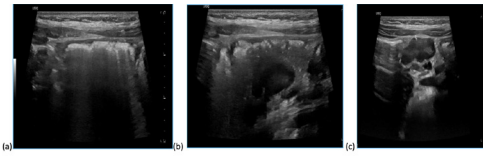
Graded compression sonography revealed enlarged multiple mesenteric lymph nodes, the largest is in figure (c). It is very clear how bowel gas was displaced from a-c when using grade compression sonography.
